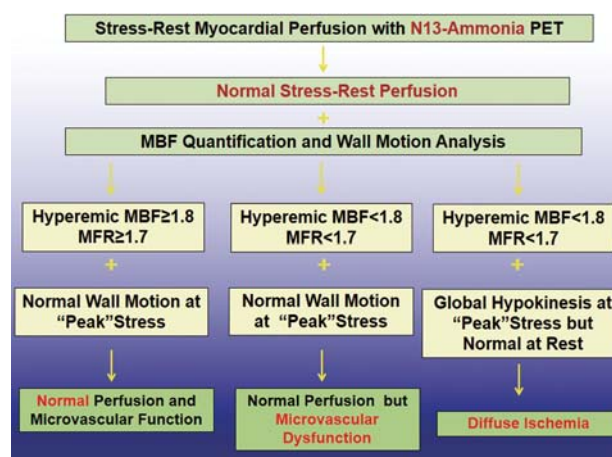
Algorithm for the Integration of ^{13}N -ammonia PET/CT Perfusion Images, MBF, and Wall Motion Analysis for Differentiation between Microvascular Dysfunction and Diffuse Ischemia
